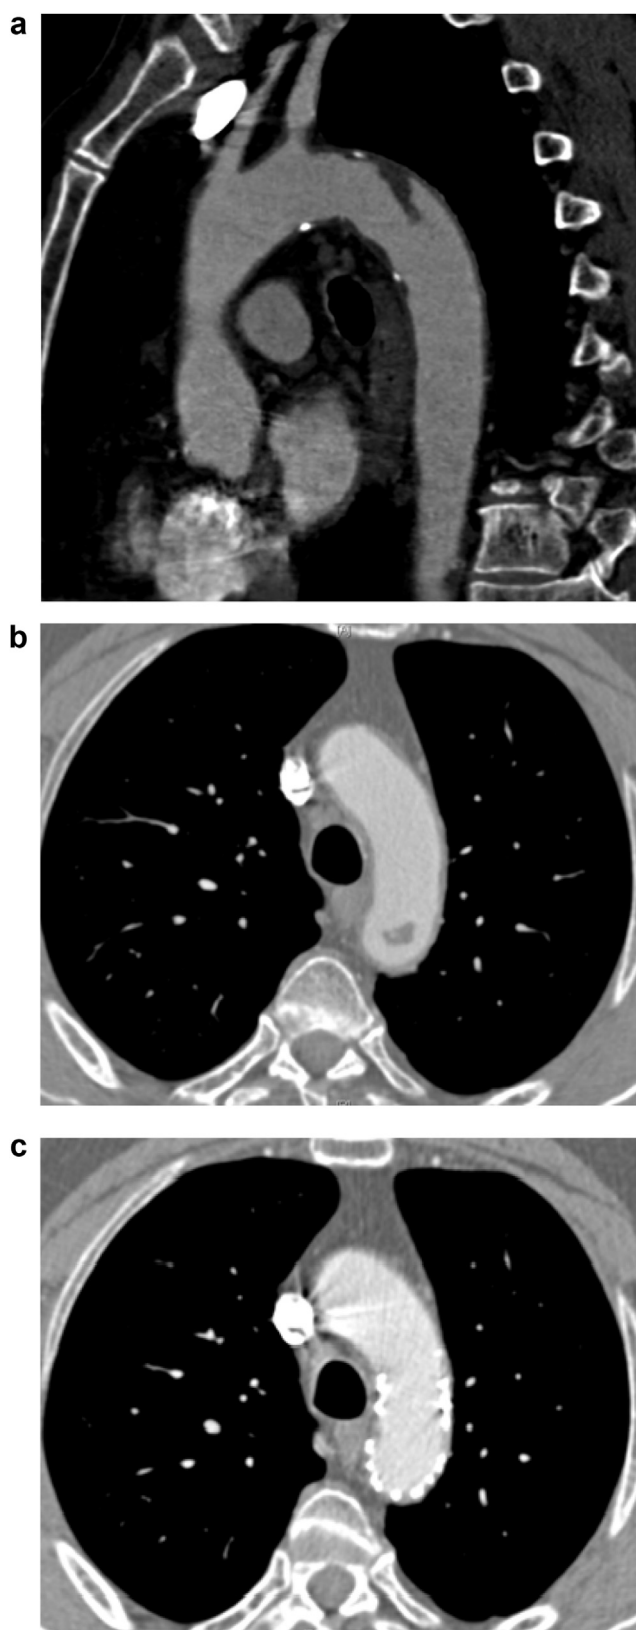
A 76 year-old-patient with asymptomatic thrombus in the aortic isthmus. (A) Sagittal view of CT scan shows a sessile thrombus originating 2 cm below the left subclavian artery. (B) Axial view shows the floating aspect of the thrombus. (C) Axial view of the post-operative CT scan shows no recurrence 32 months after stentgraft implantation.
